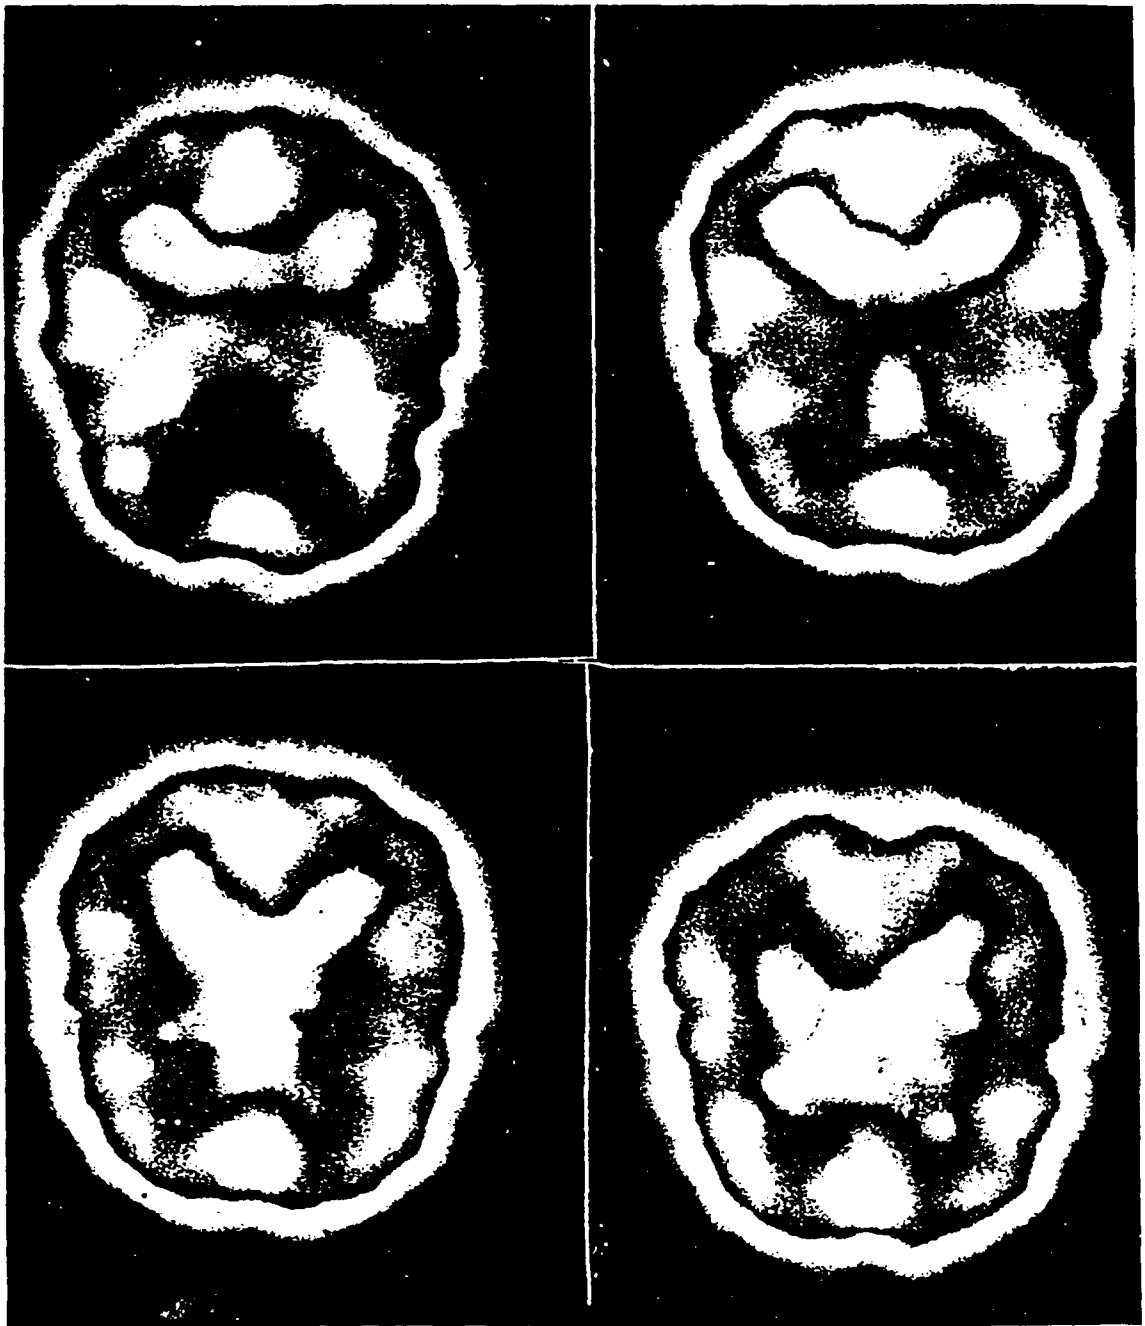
A. shows normal HMPAO ^{99m}Tc SPECT STUDY in Transaxial, ^{99m}Tc HMPAO, and separation of grey matter and white matter perfusion.
